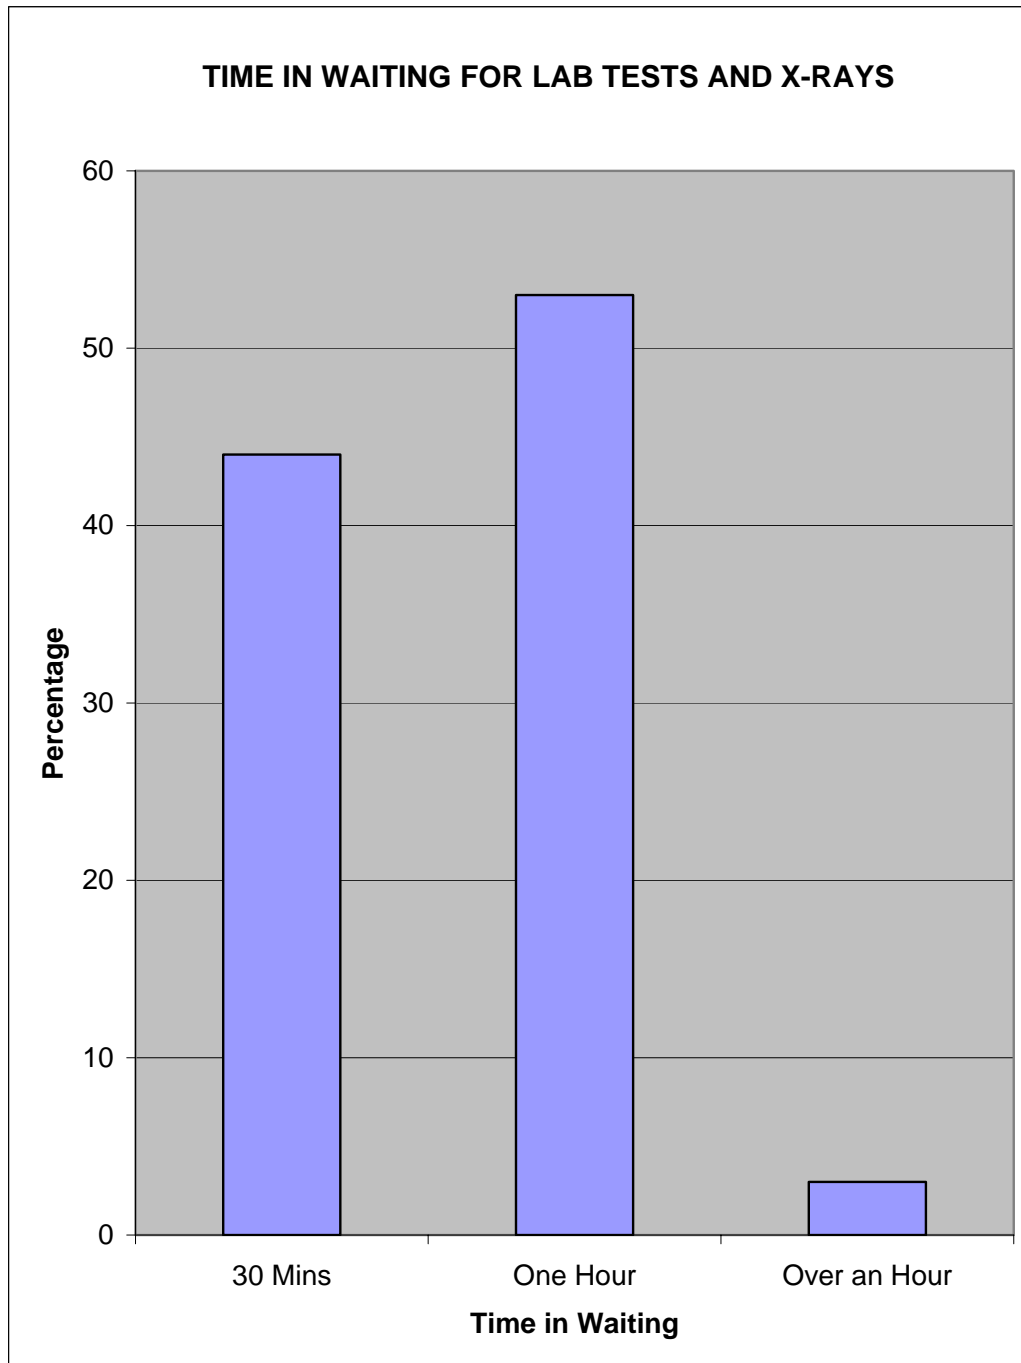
Time in Waiting for Lab Tests and X-Rays
